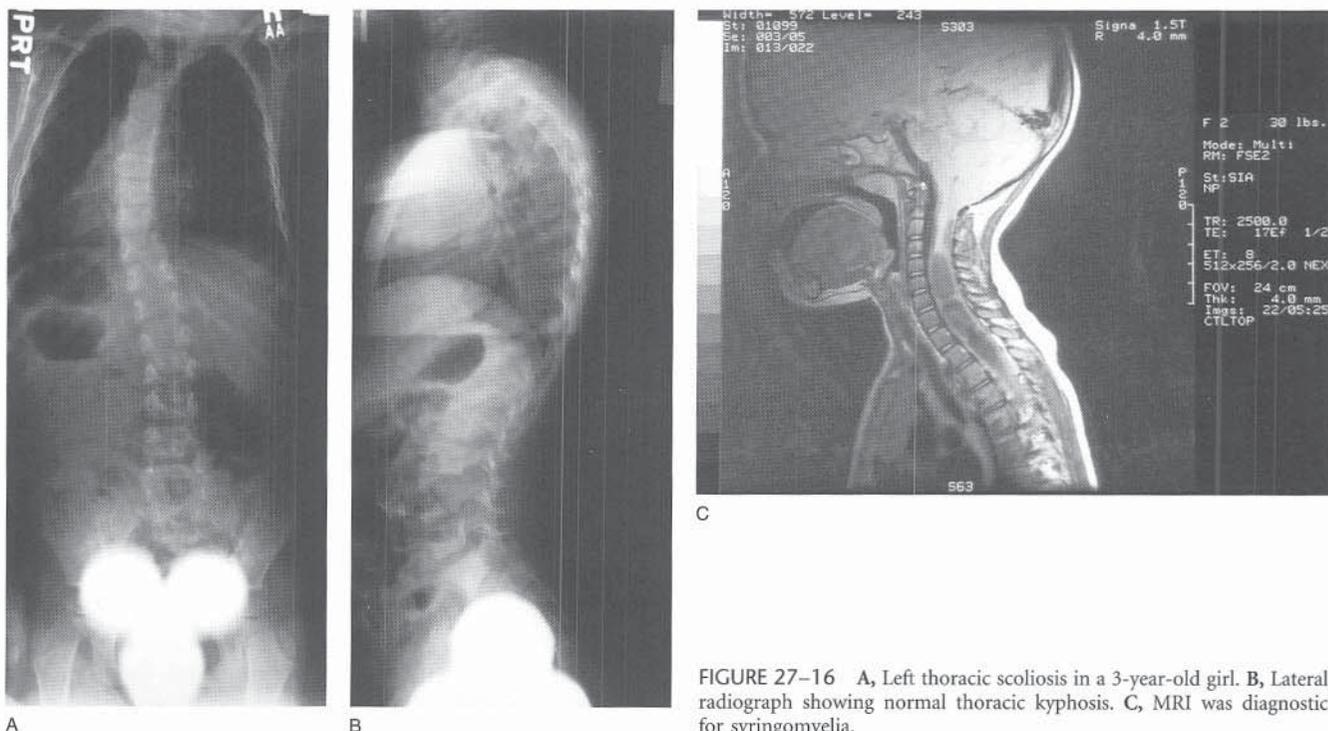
A, Left thoracic scoliosis in a 3-year-old girl. B, Lateral radiograph showing normal thoracic kyphosis. C, MRI was diagnostic for syringomyelia.
